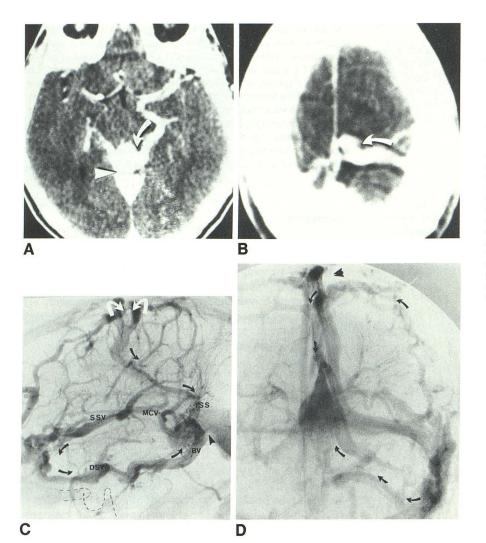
A and B, Contrast-enhanced CT scans. Two enlarged vascular structures corresponding to basal vein of Rosenthal (curved arrow in A) and to a vein of Trollard (curved arrow in B) are shown. Vein of Galen aneurysm is visualized with a "weblike" appearance distally (arrowhead in A) followed by moderate ectasia of straight sinus.
